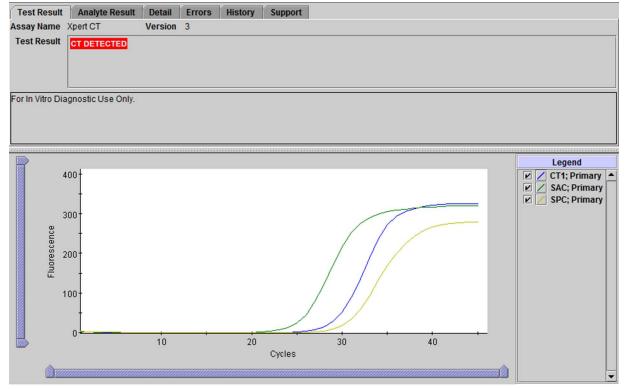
An Example of a CT DETECTED Result
